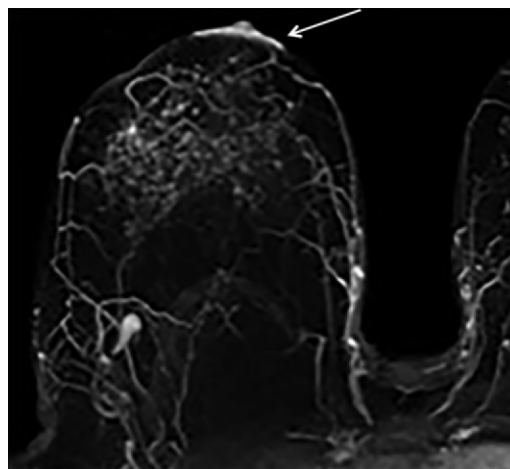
Skin lesion. Axial contrast-enhanced maximum intensity projection MR image shows punch biopsy-proven eczema of the right nipple-areolar complex manifesting with skin thickening and enhancement (arrow).
